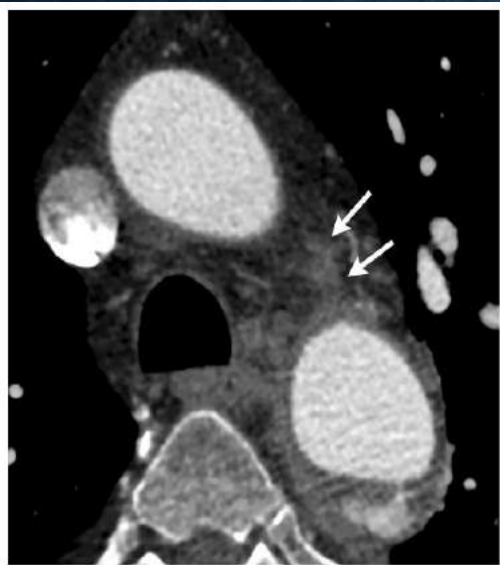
57 year-old male with a chronic, 105 day-old type B aortic dissection. CT scan at level of aortic arch shows peri-aortic soft tissue opacities (arrows)
